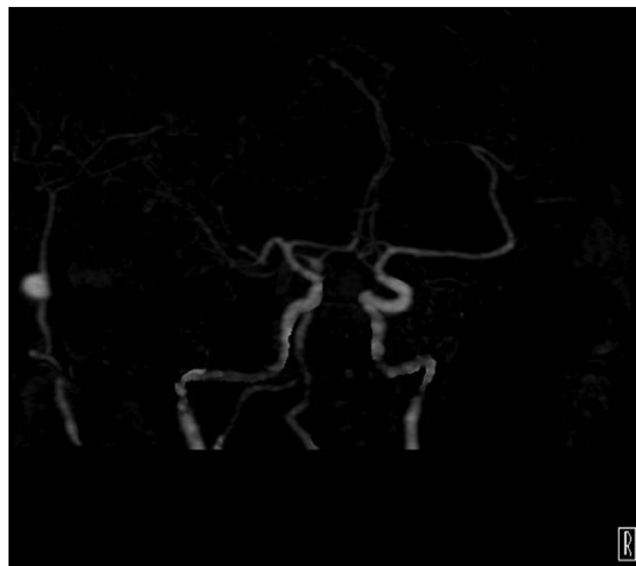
Computed tomography angiography shows a superficial temporal artery pseudoaneurysm.
